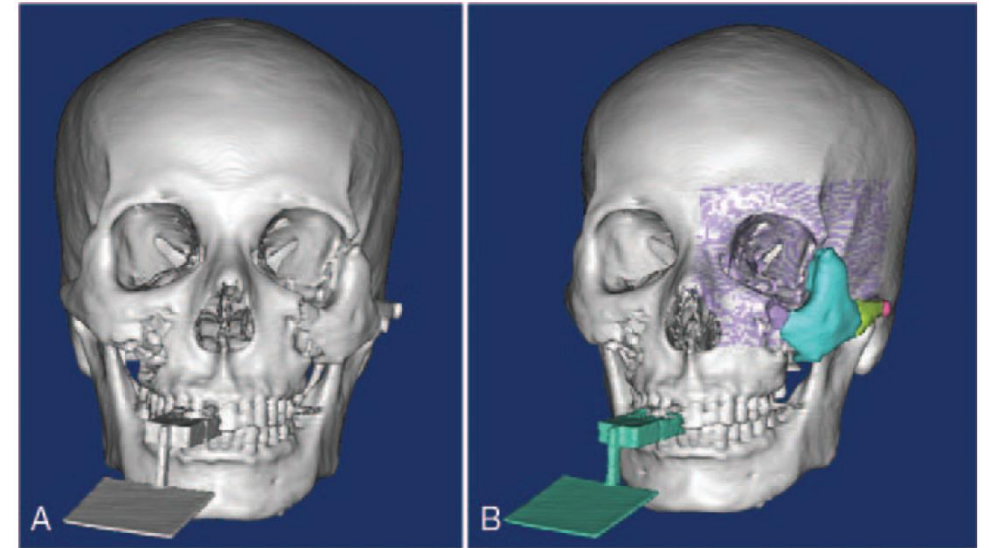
A: Reconstructed 3D model through original CT data; B: Segmenting fracture ends and visual identification marks in the injured area
